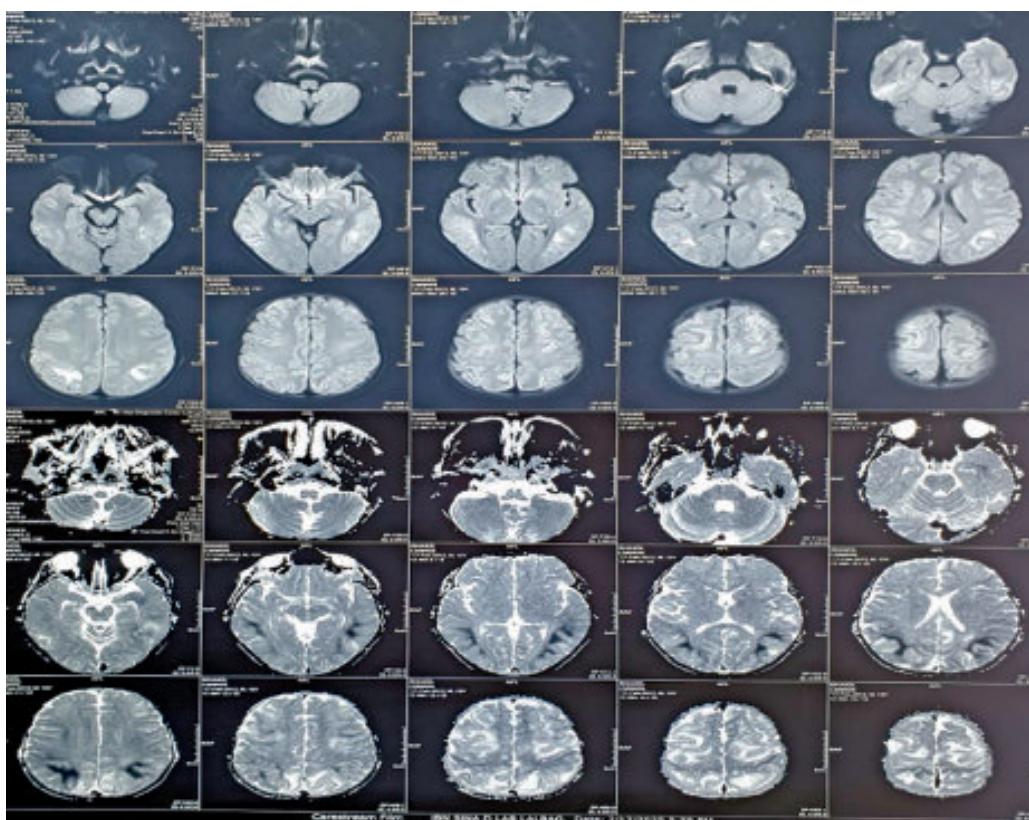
T1-weighted MRI shows bilateral symmetrical hypointense area in fronto-parietal and occipital area
